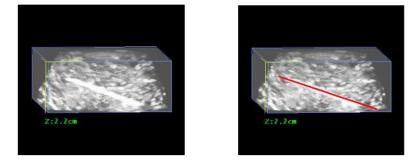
Segmentation of a needle in 3D Ultrasound Image using 3D Improved Hough Transform [6].
